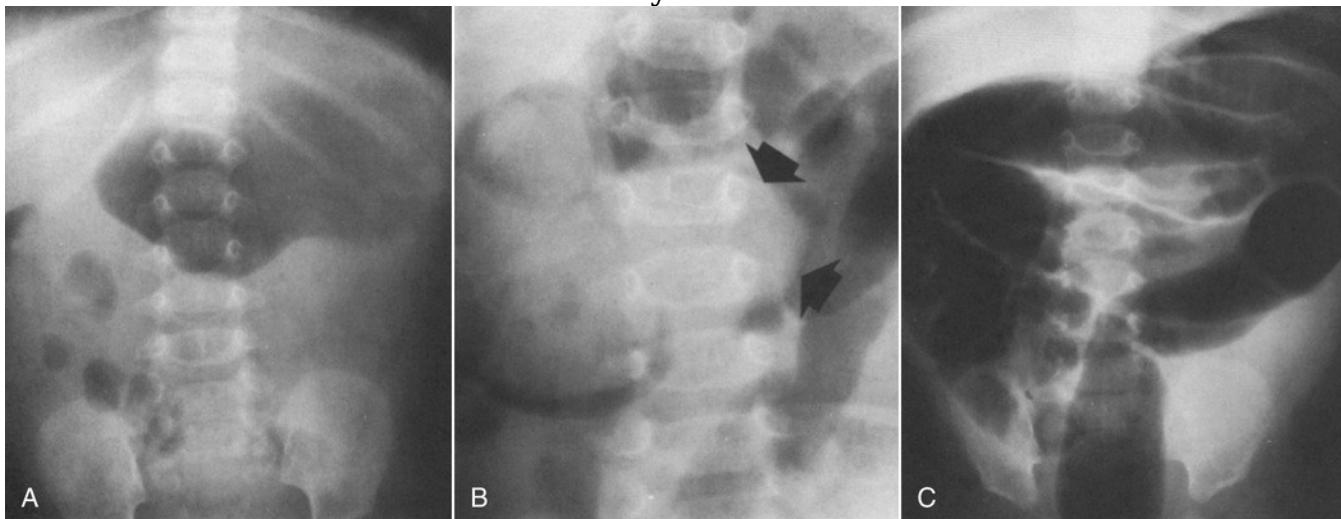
Intussusception. A, Plain abdominal radiograph demonstrating a gas-filled stomach and relatively little gas in the distal end of the bowel. This baby had typical clinical features of intussusception and a palpable upper abdominal mass. Therefore, an enema with air was performed. B, The intussusception (arrows) is outlined by air. C, Reduction is proved by air refluxing into loops of small bowel. (From Burg FD, Ingelfinger JR, Wald ER, editors: *Gellis and Kagan's current pediatric therapy*, ed 15, Philadelphia, 1999, Saunders.)
